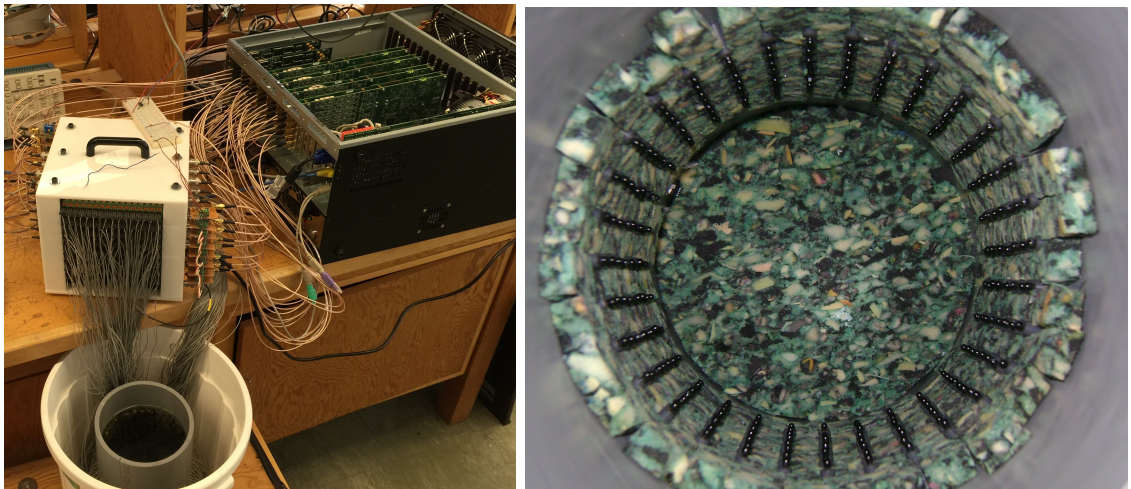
Ultrasound tomography system at the University of Manitoba. This system has 8 rings, each of which consists of 32 transducers.
